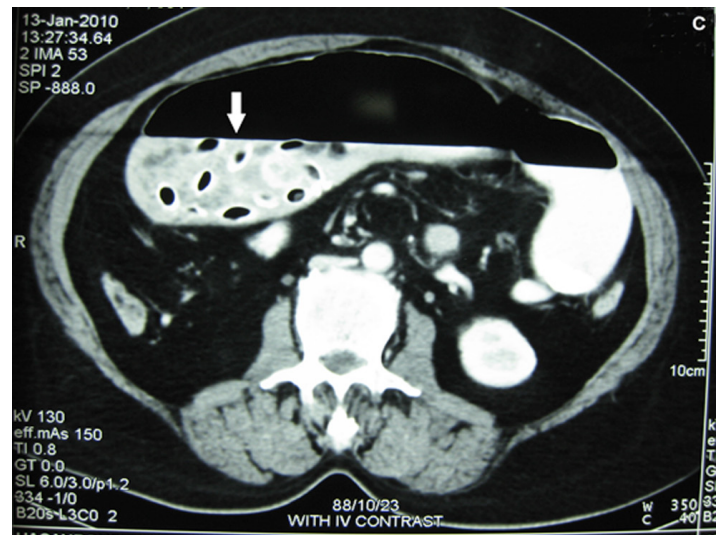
Contrast-enhanced abdominal computed tomography transverse image showing round calcified mass with areas of air (arrow).
